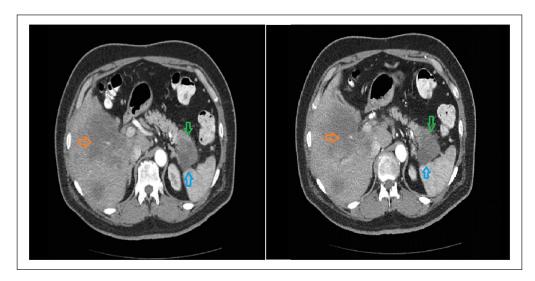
The CT scan of the abdomen shows heterogeneous soft tissue density mass (blue arrows) originating from the swollen tail of the pancreas (green arrows) with multiple hypo-dense lesions of varying sizes in the liver (orange arrows). CT: computed tomography.
